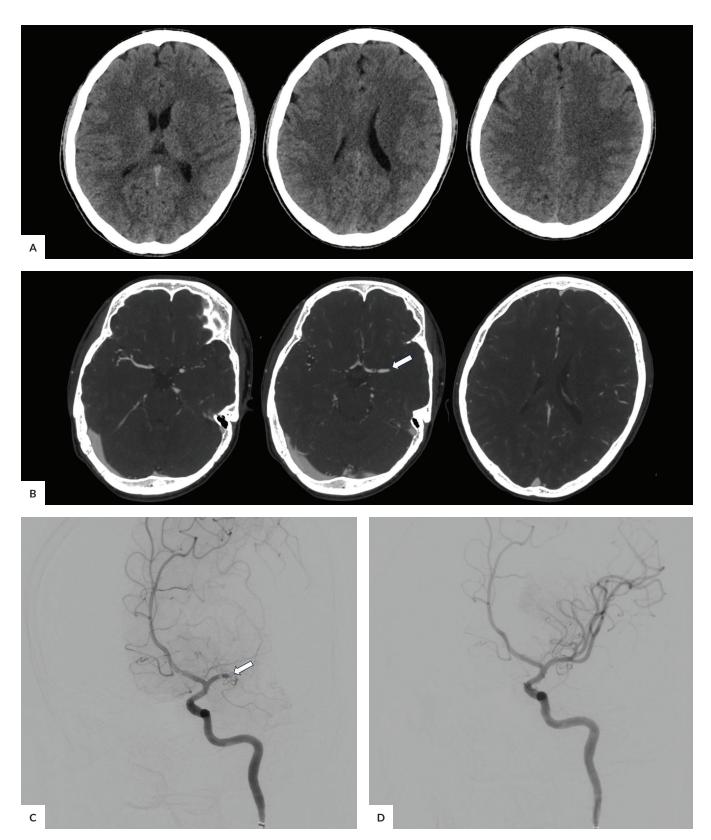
A 21-year-old male with rheumatic heart disease. (A) plain cranial CT scan demonstrated a hyperacute left middle cerebral artery infarct ASPECTS 7. (B) CTA showed occlusion of the distal M1 segment of the left middle cerebral artery (arrow). (C) Cerebral angiogram of the left internal cerebral artery again revealed an occlusion of the distal M1 segment of the left middle cerebral artery (arrow). (D) Post endovascular thrombectomy angiogram showed TICI 3 reperfusion.
